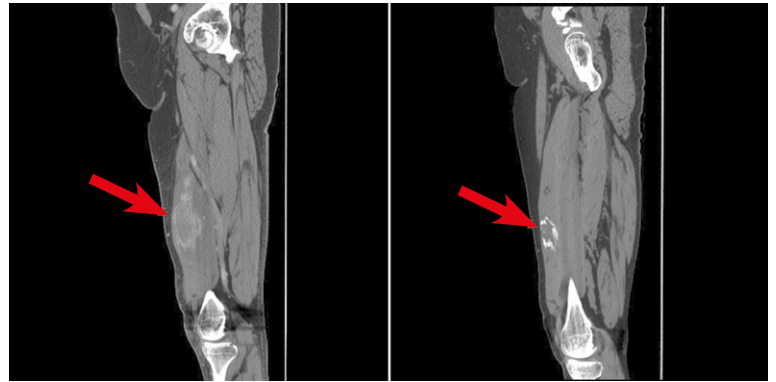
Heterotopic Ossification shown with initial hyperemia without calcification at presentation (left- red arrow) with increasing organized calcification seen after 4 months on Non-contrast CT (Right-red arrow).
